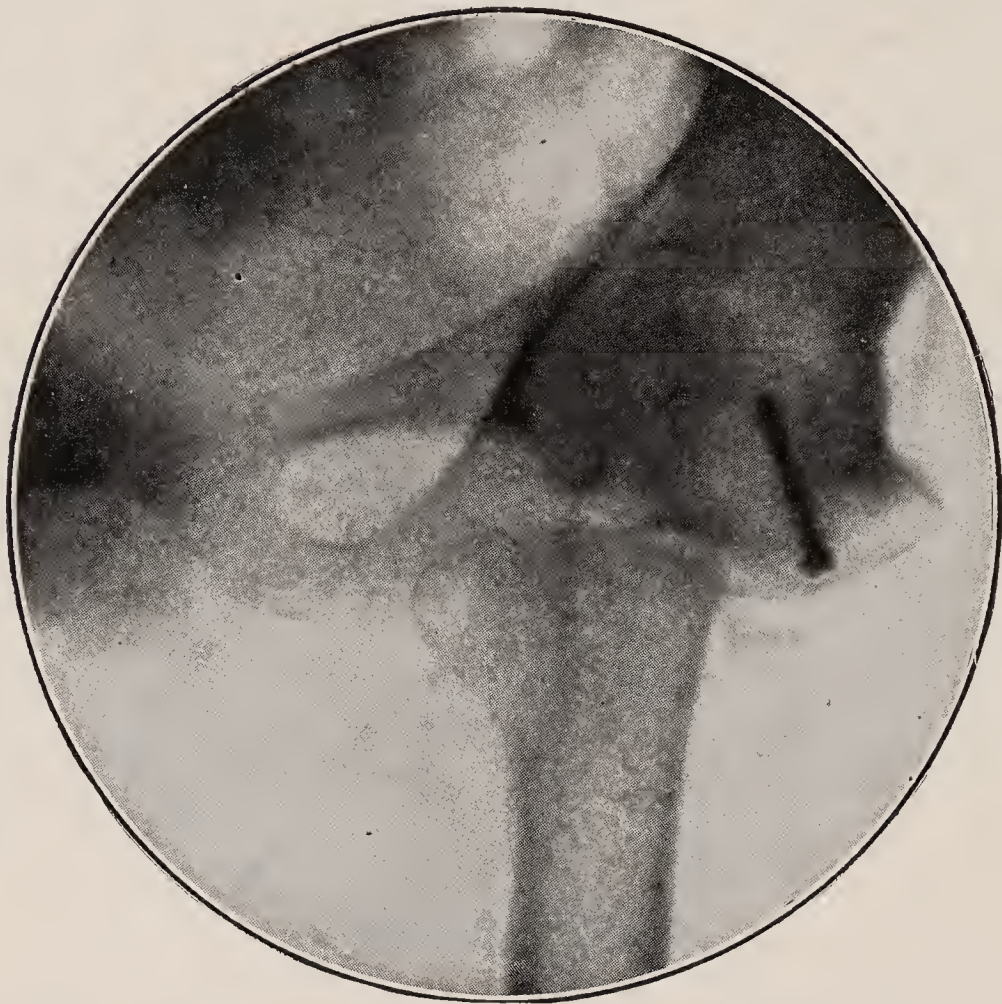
X-ray of Jones' method for pseudarthrosis of the hip.
